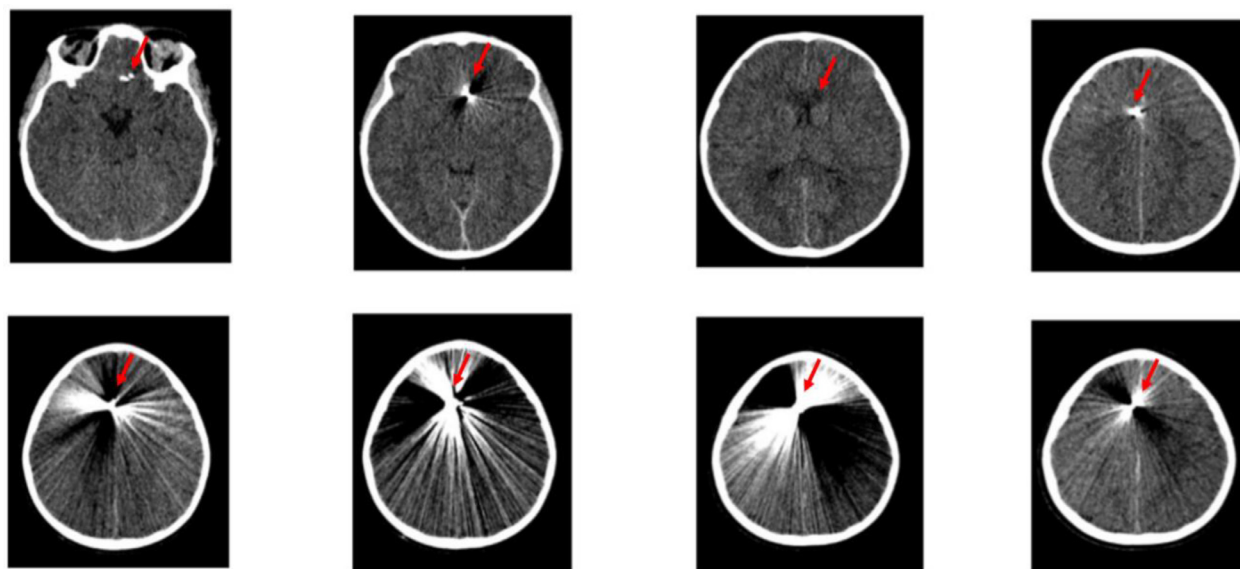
Head computed tomography (CT) without contrast showing the bullet track through the medial anterior frontal lobes with retained fragments along the track and larger bullet fragment superiorly in the right frontal lobe as indicated by the red arrows. There is an associated parenchymal contusion with small hemorrhage and edema at the genu of the corpus callosum and along the falx cerebri.
